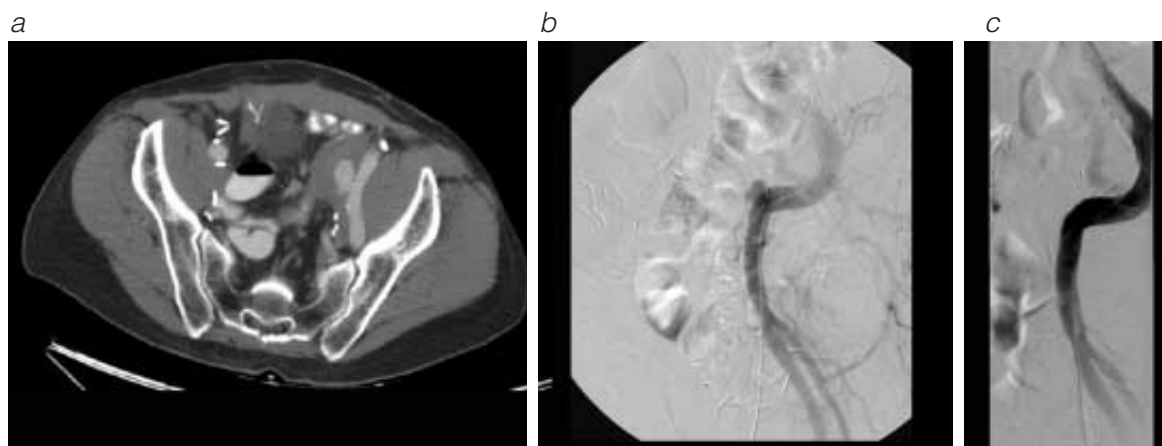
Placement of covered stent. Shown is endovascular repair of an external iliac artery aneurysm. The patient presented with left groin pain several months after undergoing urologic surgery. (a) CT scan demonstrates a left external iliac artery pseudoaneurysm. (b) Angiogram demonstrates the same pseudoaneurysm. (c) Shown is the left external iliac artery after covered stent placement successfully excluded the pseudoaneurysm.
